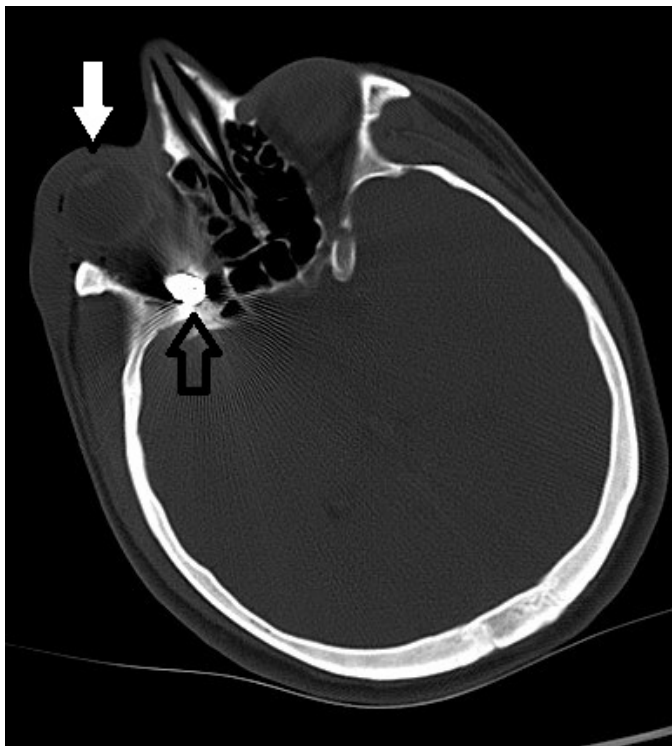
The bullet nucleus is seen in the retro-orbital region (black arrow). The eyeball boundaries are seen normally (white arrow) on orbital computed tomography
